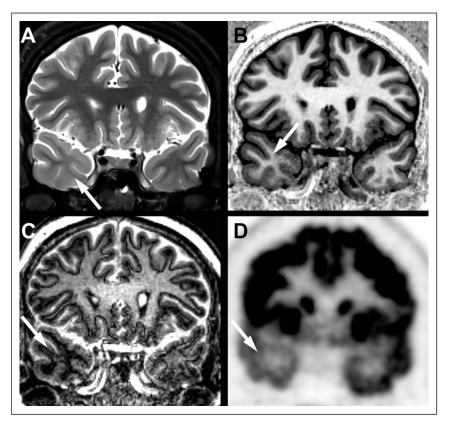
In Patient 1, coronal (a) T2-weighted and (b) SPACE inversion recovery sequences show subtle blurring of the gray-white junction with slight increase in T2 signal in the subcortical white matter of the right temporal pole (arrow). (c) Coronal 3D-EDGE shows unequivocal diffuse hypointensity of the subcortical white matter of the right temporal pole (arrow). (d) Coronal FDG-PET reveals diffuse hypometabolism of the right temporal pole (arrow).
